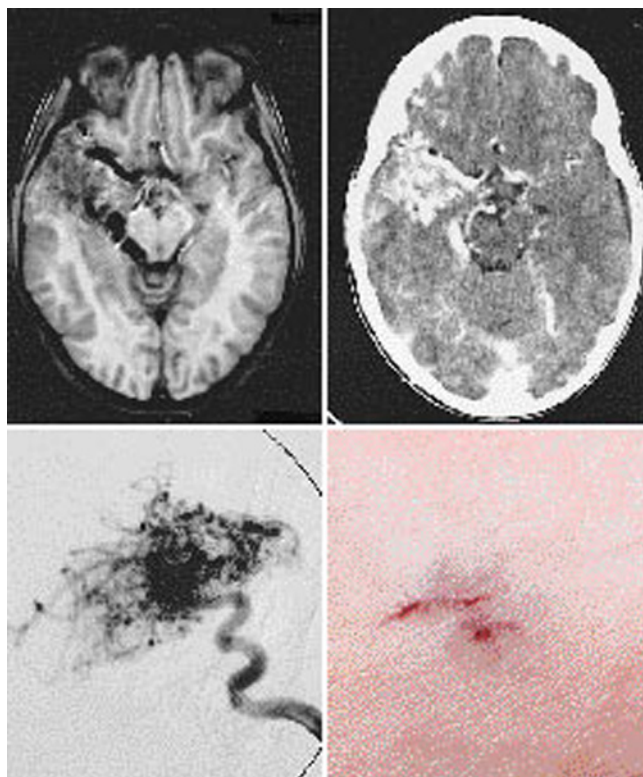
Case 4. Magnetic resonance (MR) image, infused computerized tomography (CT) scan (*upper*), internal carotid artery angiogram, and photograph showing vascular nevus. The MR image (*upper left*) and CT scan (*upper right*) demonstrate abnormally enlarged arteries and veins and a nidus of abnormal blood vessels in the right temporal lobe. Carotid angiography (*lower left*) confirms this lesion to be a cerebral arteriovenous malformation. The photograph (*lower right*) of the forearm demonstrates the spiderlike vascular nevus measuring approximately 0.75 cm in largest diameter diagnosed by inspection and palpation.
